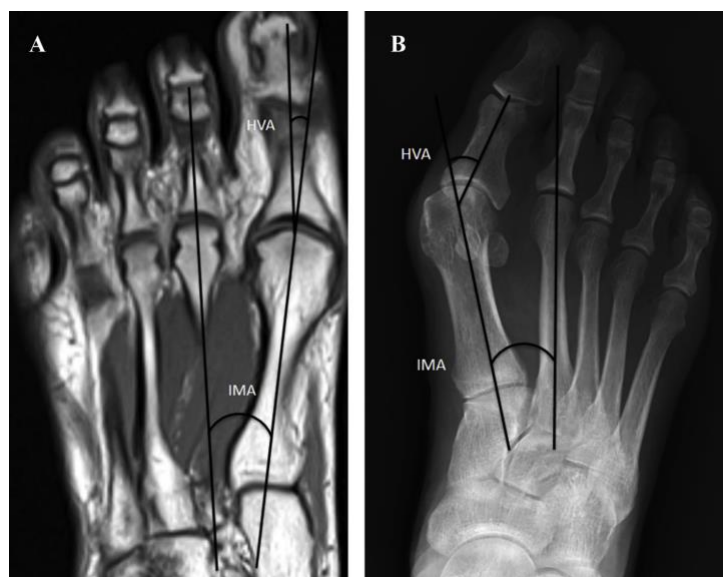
HVA and IMA measurements on MRI and x-ray. Hummela, et al., (2019) European Journal of Radiology. VOLUME 113, P24-31
